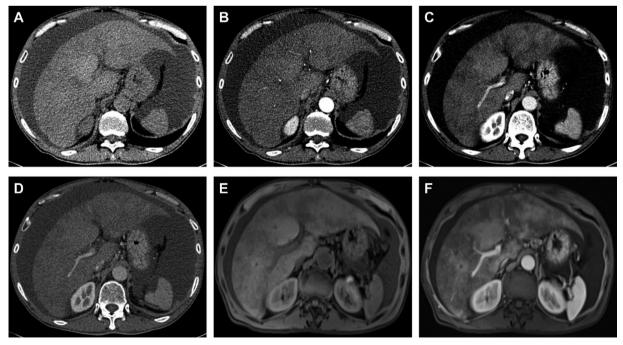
(abstract: FRI-517): 67-year-old man diagnosed with gynura segetum-induced HSOS received contrast-enhanced CT and MRI scan. (A–D) images of plain and contrast-enhanced CT scan; (A) plain CT scan; (B) arterial phase; (C) porta-venous phase; (D) equilibrium phases. (E–F) images of pre-contrast and portal-venous phase on dynamic contrast-enhanced MRI scan; (E) pre-contrast MRI scan; (F) portal-venous phase of MRI scan.
